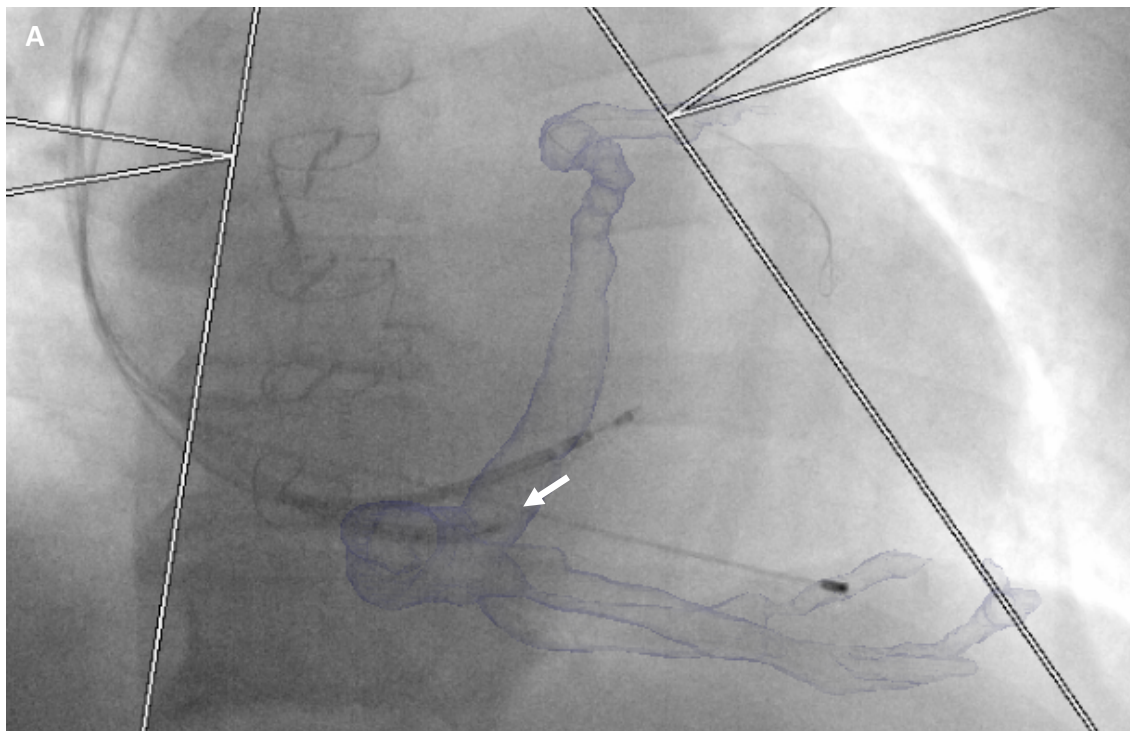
CT derived coronary venous anatomy
